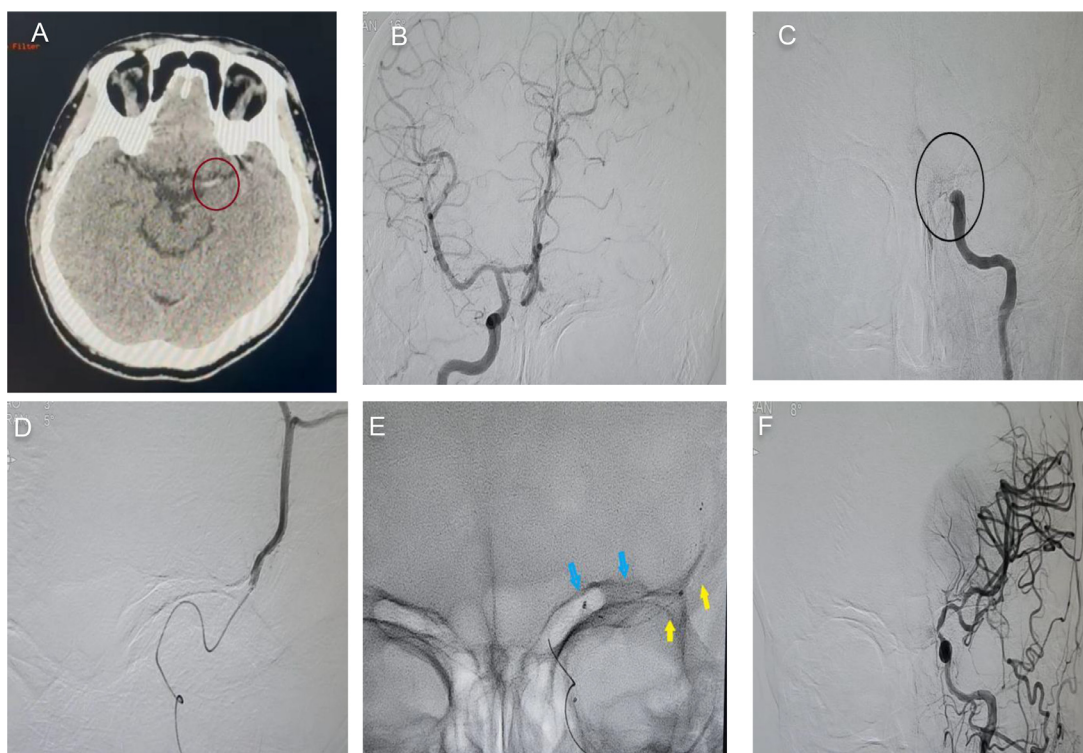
(A) Axial computed tomography (CT) scan of the head showing middle cerebral artery (MCA) dense sign in Left side (red circle). A cerebral digital subtraction angiography in anteroposterior from the right internal carotid artery (ICA) showed preserved left anterior cerebral artery vascularization through Acom (B). Injection from left ICA showed total occlusion from distal part of cavernous segment (black circle) which is suspected until M1 segment of MCA based on CT scan (C). Selective injection showed the microcatheter has passed beyond the clot and 2 mechanical thrombectomy was attempted with no recanalization (D) Double stent retriever technique was performed with 2 microcatheters placed in superior segment (blue arrow) and inferior segment of MCA (yellow arrow) (E) with complete recanalization (F).
